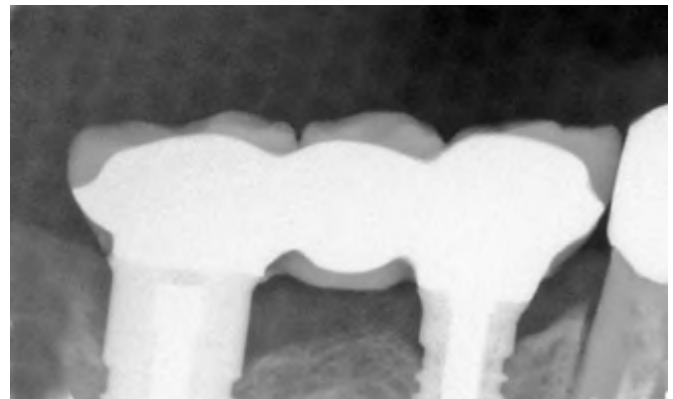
Radiograph of the prosthesis in place that demonstrated excellent marginal fit between the retainers and the abutments.
